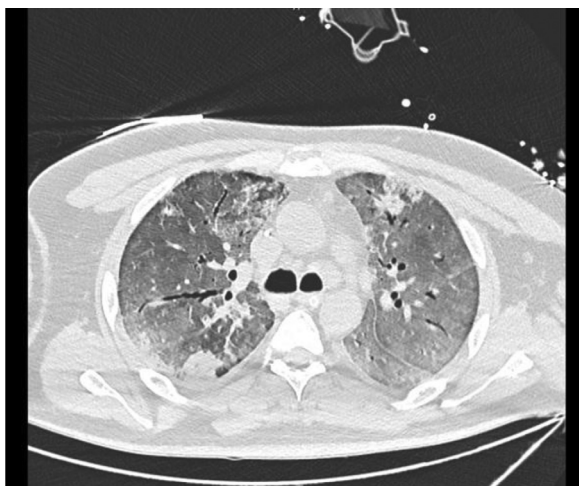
CT chest showing diffuse ground gland abnormalities with peripheral consolidations. Findings suggestive of severe COVID-19 infection.
